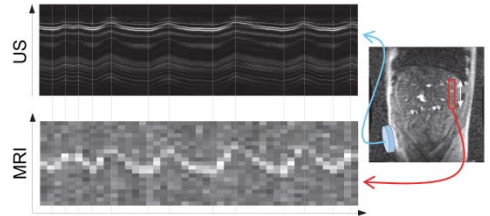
US and MRI data were acquired in a synchronized manner, at 1.6 fps and 156 fps, respectively.
